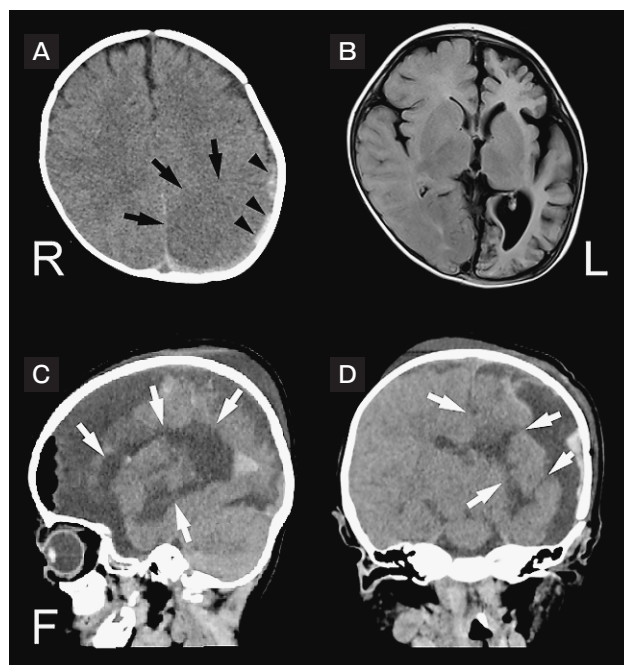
Neuroimaging. (A) A computed tomography (CT) scan taken immediately after the status epilepticus shows an acute subdural hematoma in the left parietal region (black arrowheads), and a broad low-density area with blurred corticomedullary borders in the left parietal and occipital lobes (black arrows). (B) A magnetic resonance imaging (MRI) fluid-attenuated inversion recovery (FLAIR) image taken at 10 months of age shows marked cerebral atrophy of the left hemisphere and enlargement of the left lateral ventricle. (C, D) A CT scan taken after the hemispherotomy shows the fiber disconnection (white arrows) (C, sagittal view; D, coronal view) and atrophy of the left hemisphere.
